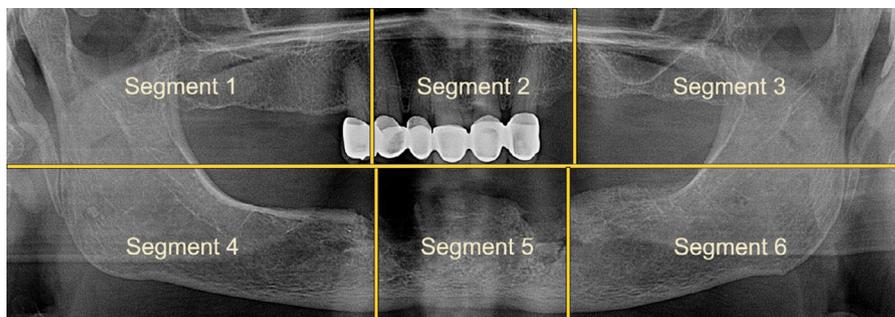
Depiction of radiographic segments used for radiographic analyses.
